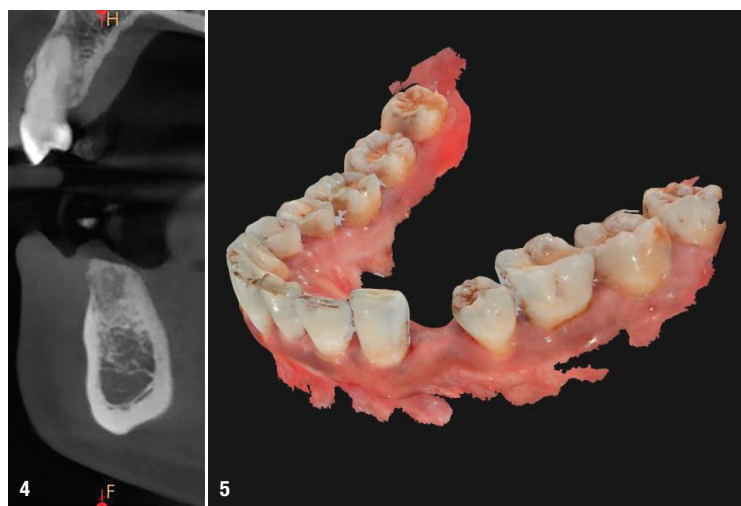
CBCT scan close up of LL4. Fig. 5: Prosthetic-driven implant planning model.
